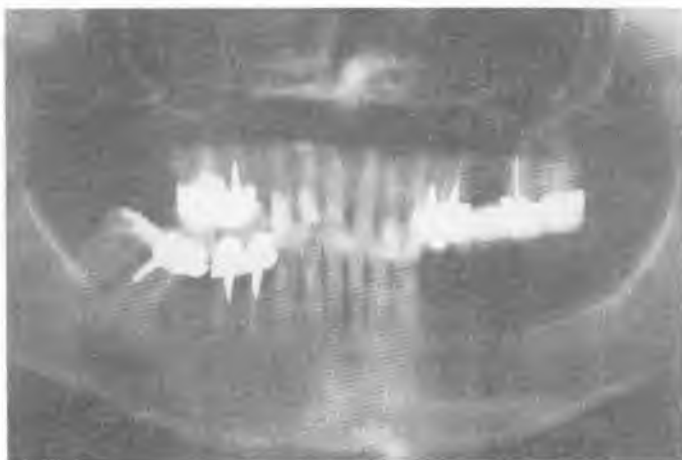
Panoramic radiographs made during the first visit
